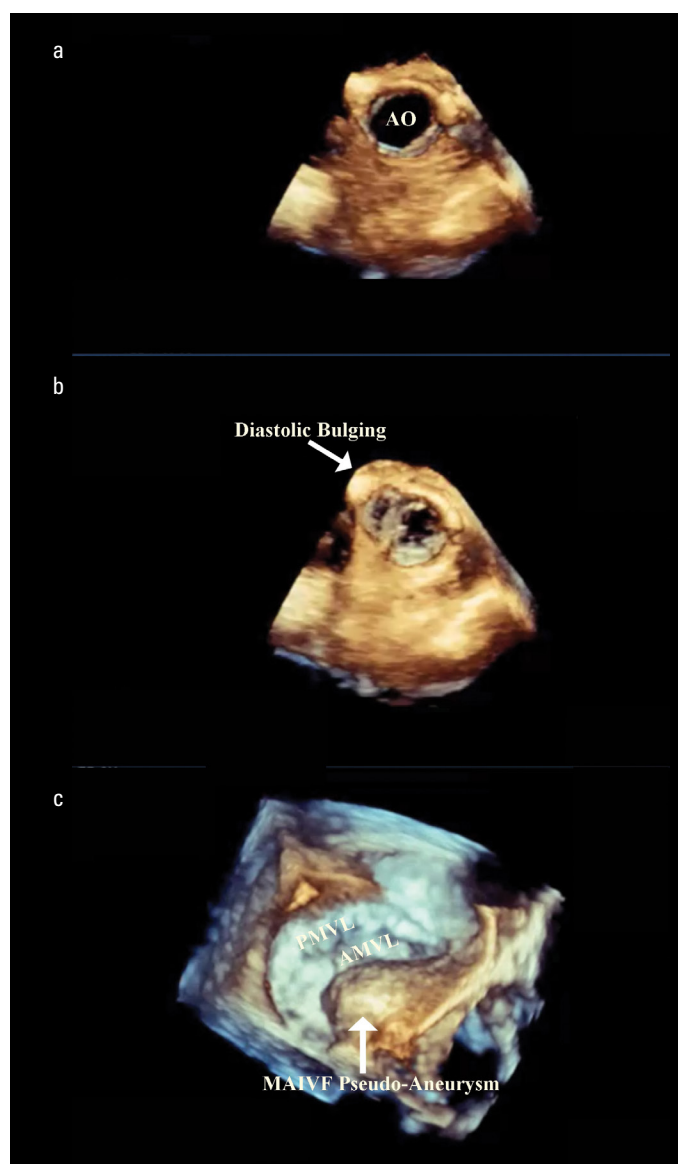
a, b, c. (a) Three-dimensional transesophageal echocardiographic view of the aortic valve in systole (b) Diastolic MAIVF bulging. (c) En face view of the mitral valve from the left atrium
